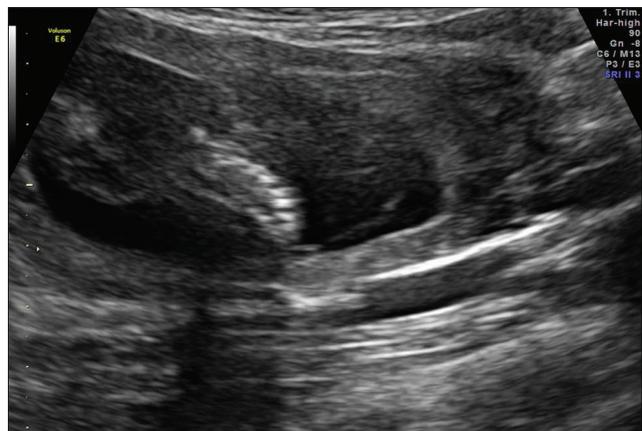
Ultrasound: Abnormal spine suggesting scoliosis
